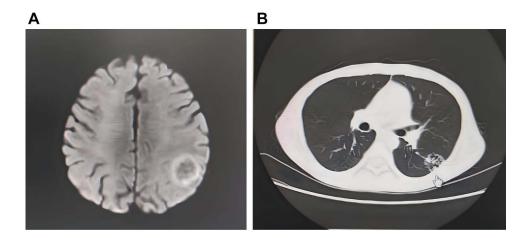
Figure I (A) Contrast enhanced Magnetic resonance imaging showed the left parietal lobe mass with ring enhancement; (B) computed tomography scan shows hollow shadows in left lung field.
